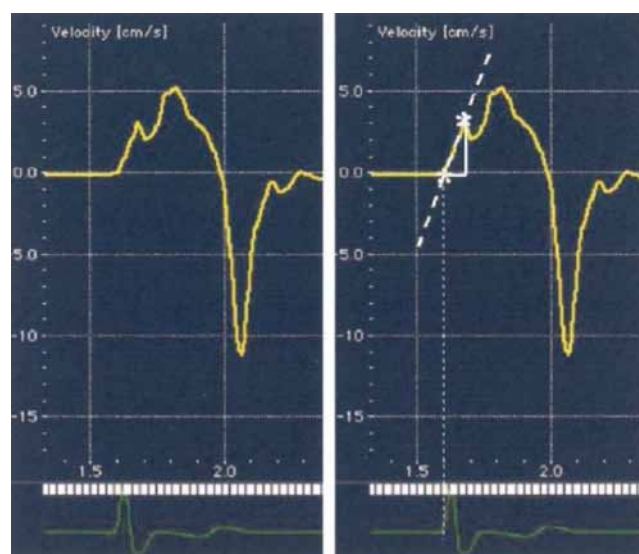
Tissue Doppler echocardiography spectral curve at the level of the tricuspid annulus. The isovolumic myocardial acceleration is calculated as the difference between baseline and peak velocity (stars) during isovolumic contraction divided by their time interval. Reproduced from Vogel et al. [30] with permission from the publisher; Copyright © 2004, the American College of Cardiology Foundation.
